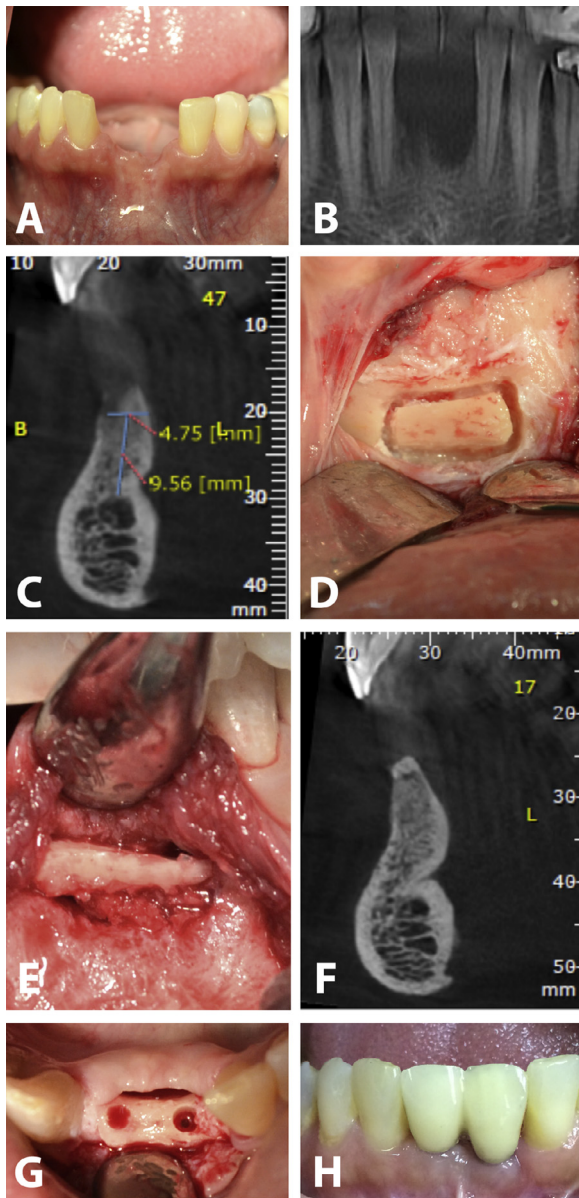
Case 2: Preoperative clinical evaluation of anterior mandibular alveolar crest missing 2 central incisors (A), radiograph of the vertical bony defect within this site (B), preoperative CBCT scan showing an osseous deficit within the defect area (C), bone graft harvest (D), augmented site exposure before implant placement (E), postoperative radiographic bone gain (F) with site preparation for 2 implants (G), and final prosthetic outcome (H).
